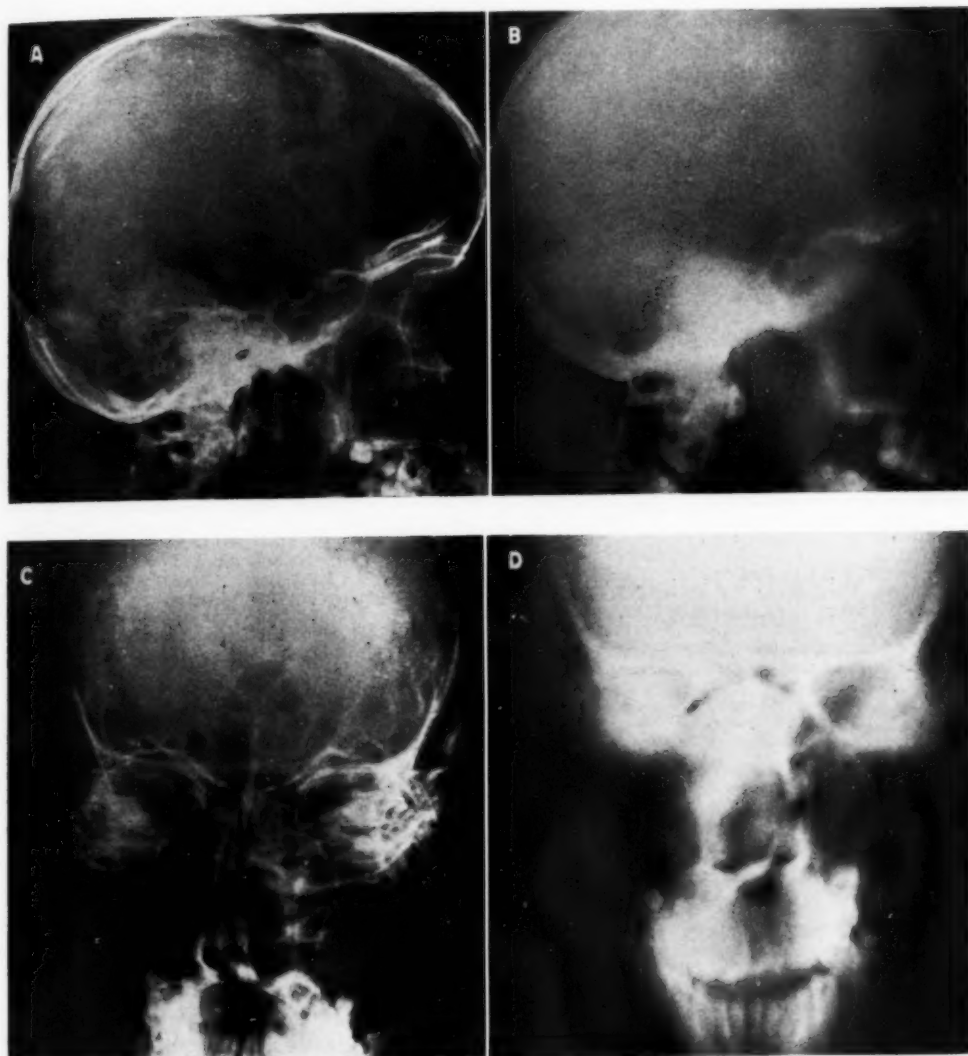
Case 4. A. Lateral roentgenogram of the skull, showing no visible skeletal change. The nasopharynx does not appear remarkable.
